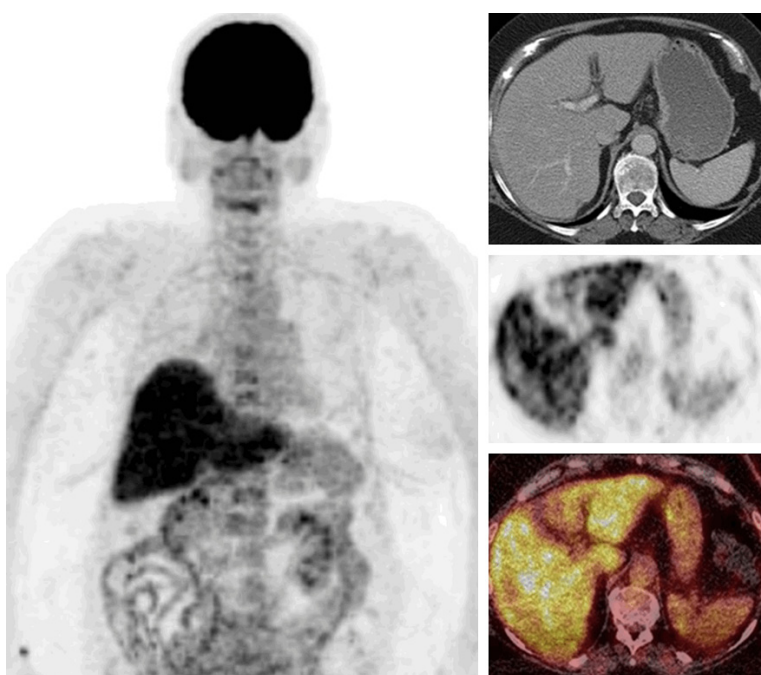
FDG PET/CT images of a case with hepatitis due to immune check point inhibitor treatment (whole body MIP, selected transaxial CT, PET, PET/CT fusion images of the liver). Diffusely and markedly increased FDG uptake in the liver with slight heterogeneity (SUVmax 9.1).
